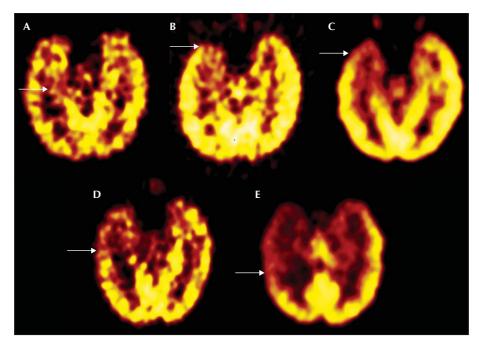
[18 F]FDG-PET. The various form of interictal temporal hypometabolism in TLE, which may include: A) the hippocampal region, B) the entire mesial temporal structures, C) the mesial temporal and temporo-polar regions, D) the latter as well as the anterior portion of the lateral temporal cortex, and E) the all temporal lobe.
